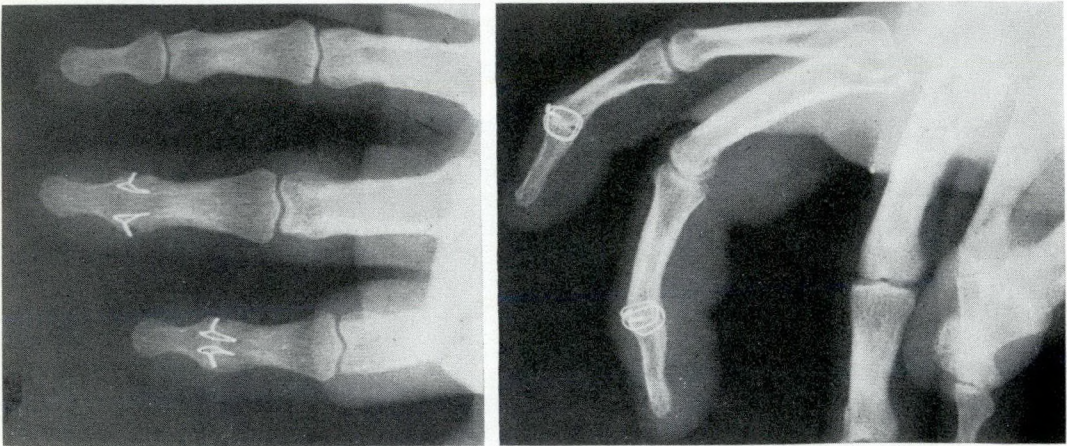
Radiographic views of the same case as in Fig. 6.
